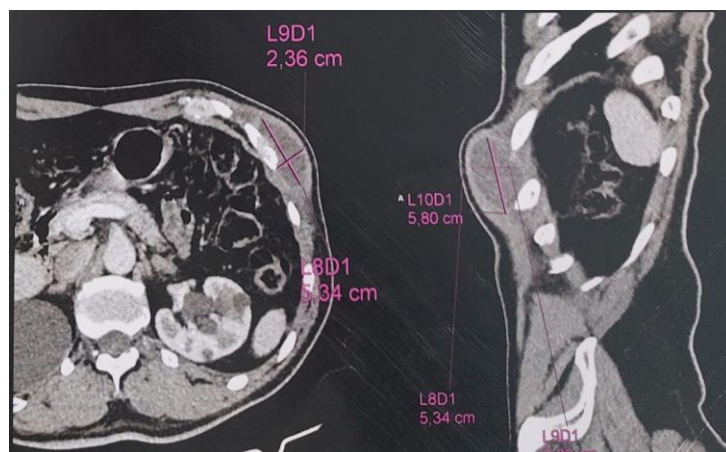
Thoraco-abdomino-pelvic computed tomography confirmed the presence of an oval-shaped formation measuring 53.4 * 23.6 mm, with thin walls and liquid content, in contact with the anterolateral and basal left thoracic wall.
